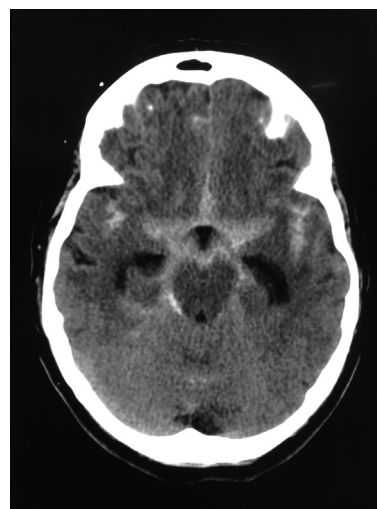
An example of the classic “starman” of subarachnoid blood that can be seen on a non-contrast head CT. This scan also shows early hydrocephalus with dilation of the temporal horns of the lateral ventricles, which can be present even after the acute SAH blood becomes isodense and is no longer distinguishable from brain tissue. Photo courtesy: Alex Koyfman, MD.
